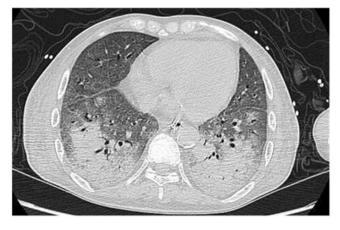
The patient's thoracic CT scan showing bilateral diffuse pulmonary infiltrates, slight pleural effusion, and pericardial effusion.
